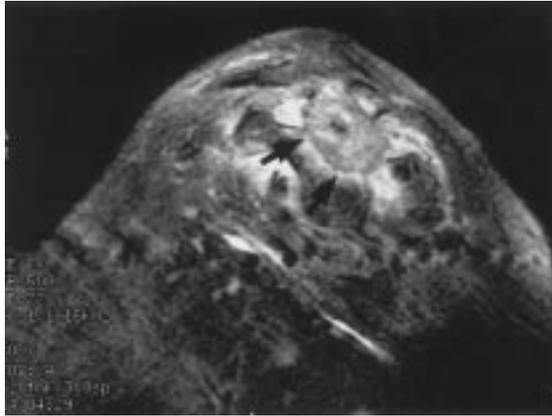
Left, Severe atrophy of the supraspinatus and infraspinatus muscles in a patient with continued pain after arthroscopic acromioplasty. Right, MR image depicts a ganglion cyst compressing the suprascapular nerve.
